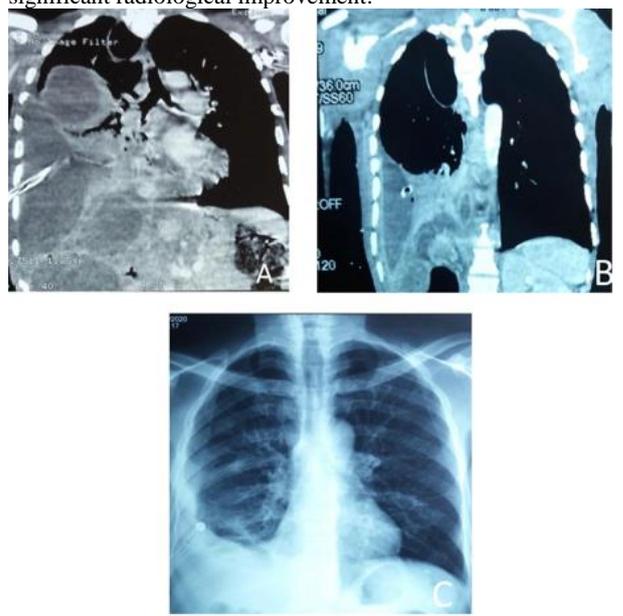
Patient #5 imaging and endoscopic iconography: A. Abdominal chest CT scan showing liver hydatid cyst communicating with lung abscess and pleural collection B. Post sphincterotomy and post pleural drainage abdominal chest CT showing regression. C. Chest x-ray showing improvement.
